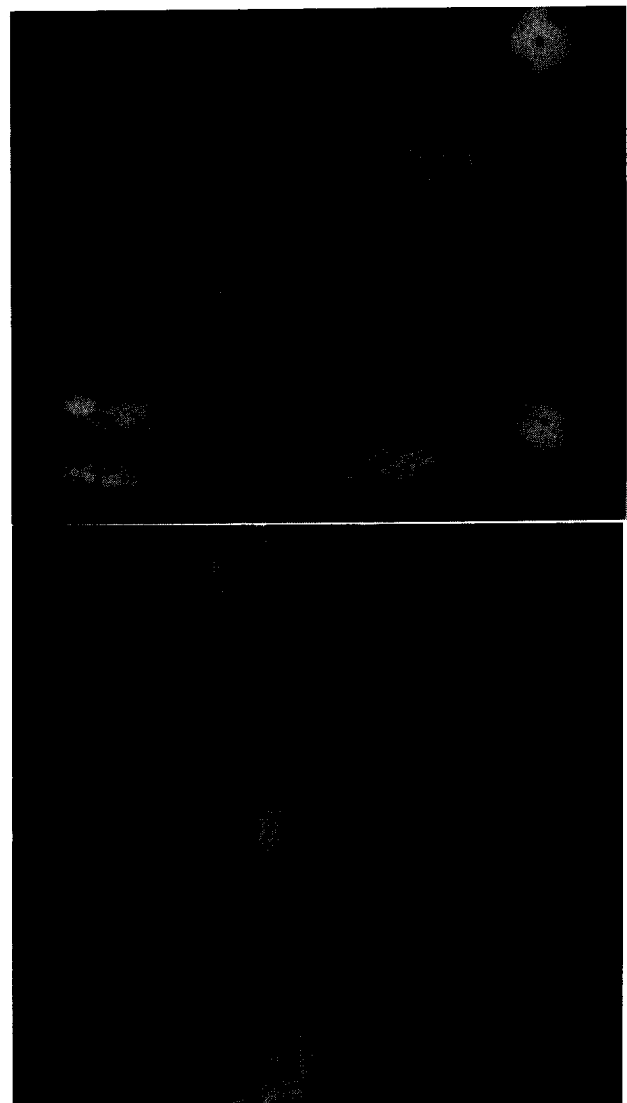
Anterior-posterior and lateral x-rays with instrumentation and lead balls at the anatomical landmarks.
